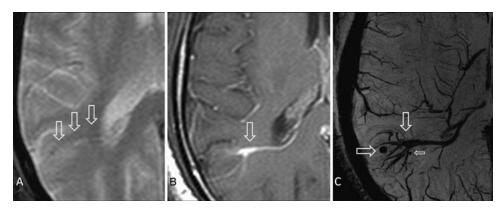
Case 1. Neuroimaging was performed routinely in this 39-year-old man after a car accident. A: On 1.5-T MR imaging, T2\*-weighted gradient echo imaging reveals very discreet signal changes in the right parietal white matter (arrows) suggestive of a DVA. B: An additional contrast-enhanced T1-weighted turbo spin echo image (B) confirms that suspicion (arrow). C: Susceptibility weighted imaging at 7 T, using MIP, precisely delineates the DVA (vertical arrow) and reveals 2 hypointense lesions (horizontal arrows) most likely to be associated CCMs.
